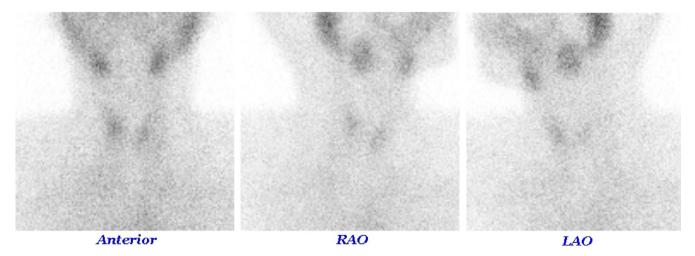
Thyroid scintigraphy. Ten minutes after IV injection of 111 MBq 99mTc-pertechnetate, static acquisition of neck was performed in anterior and anterior oblique views, by a dual head Siemens gamma camera with a low-energy high-resolution parallel-hole (LEHR-PAR) collimator (magnification 1; matrix 256 × 256, frame 100 Kc). Study reveals global, moderate to severe decreased thyroid radiotracer uptake accompanied by high background activity, compatible with subacute thyroiditis
